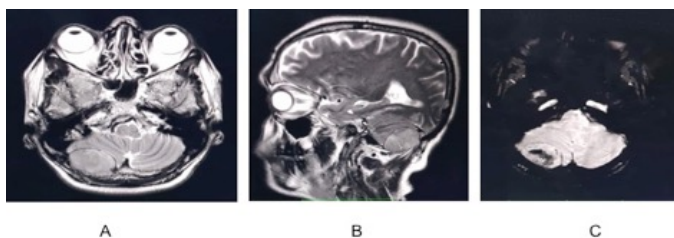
MRI Brain: (A) Axial T2 section showing soft tissue lesion of size 3.4 x 3.3cm size at the right side of occipital lobe indenting the right cerebellar lobe.
